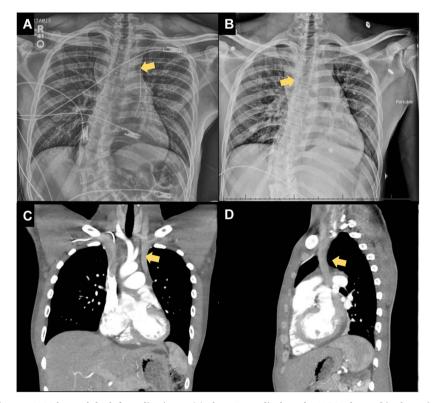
(A) Chest X-ray shows a PICC located the left mediastinum. (B) Chest X-ray displays the PICC relocated in the atrium. (C) and (D) Contrast chest CT shows the duplicate left superior vena cava.
